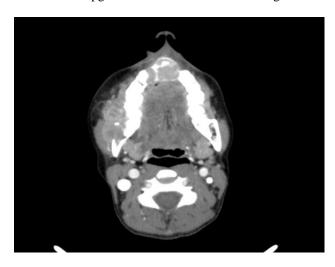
Preoperative abdominal CT, showing a lesion located at the central level in the upper maxilla that extends towards the hard palate $16 \times 17 \times 22$ mm.
